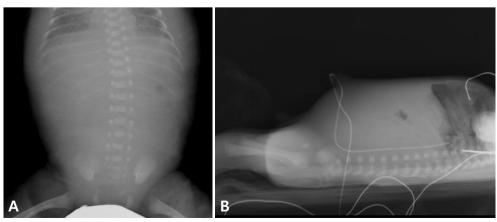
Gasless abdomen on simple abdominal radiography supine (A) and cross-table lateral (B) views show gasless or scanty gas abdomen.
